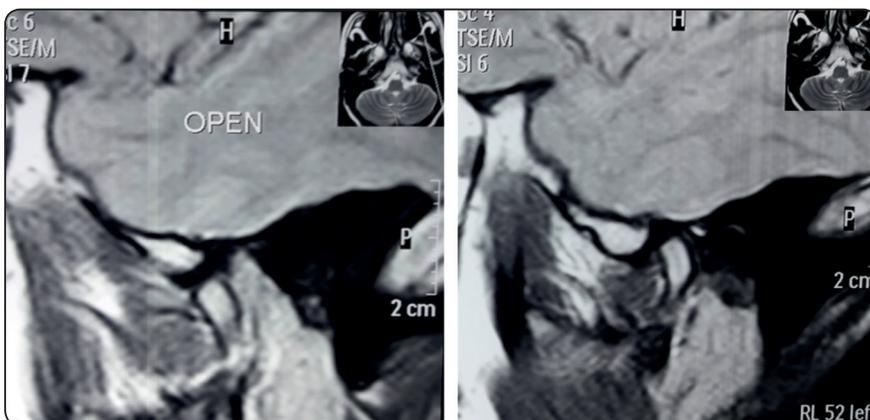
Preoperative T1 magnetic resonance imaging, sagittal view showing anterior disc displacement
